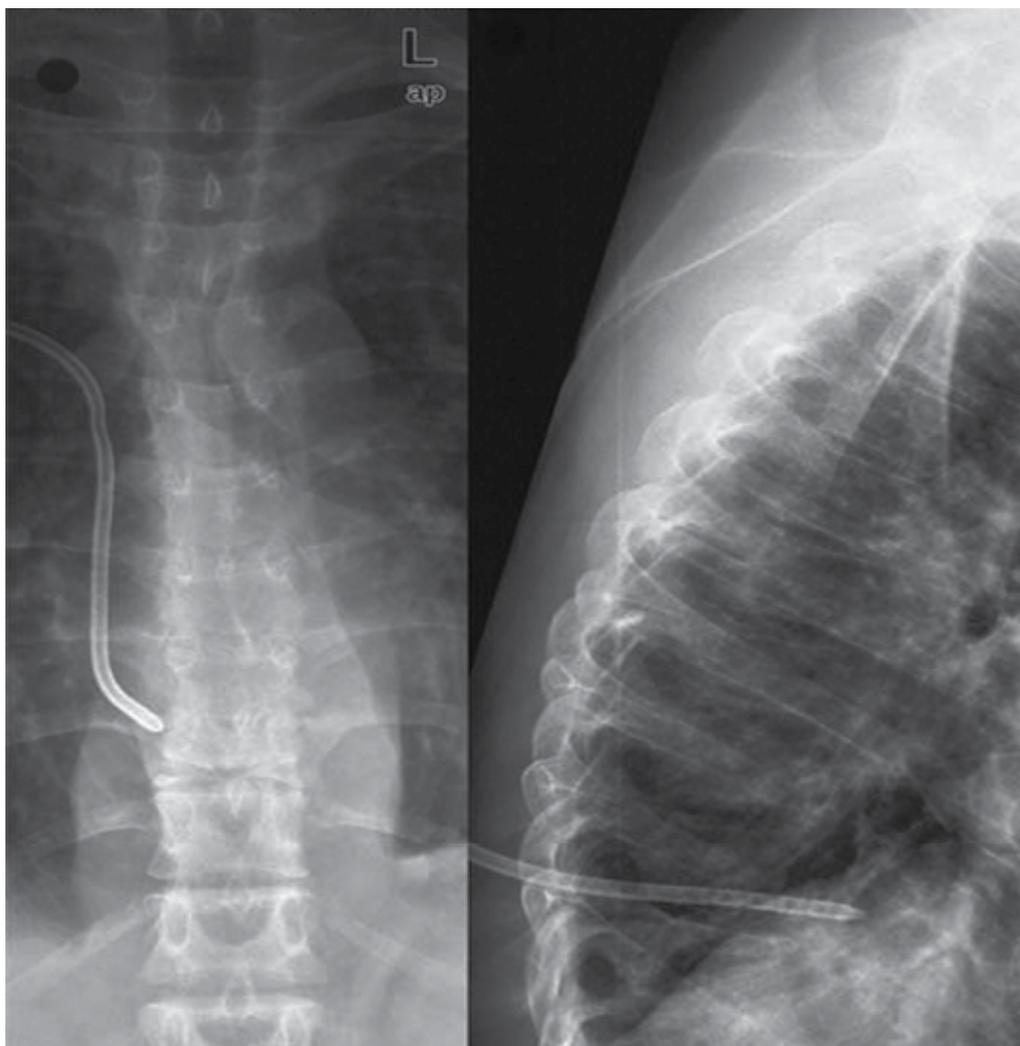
Spondylodiscitis (*Mycobacterium Xenopi*). Control X-ray after CT-guided draining of the paravertebral abscess.
